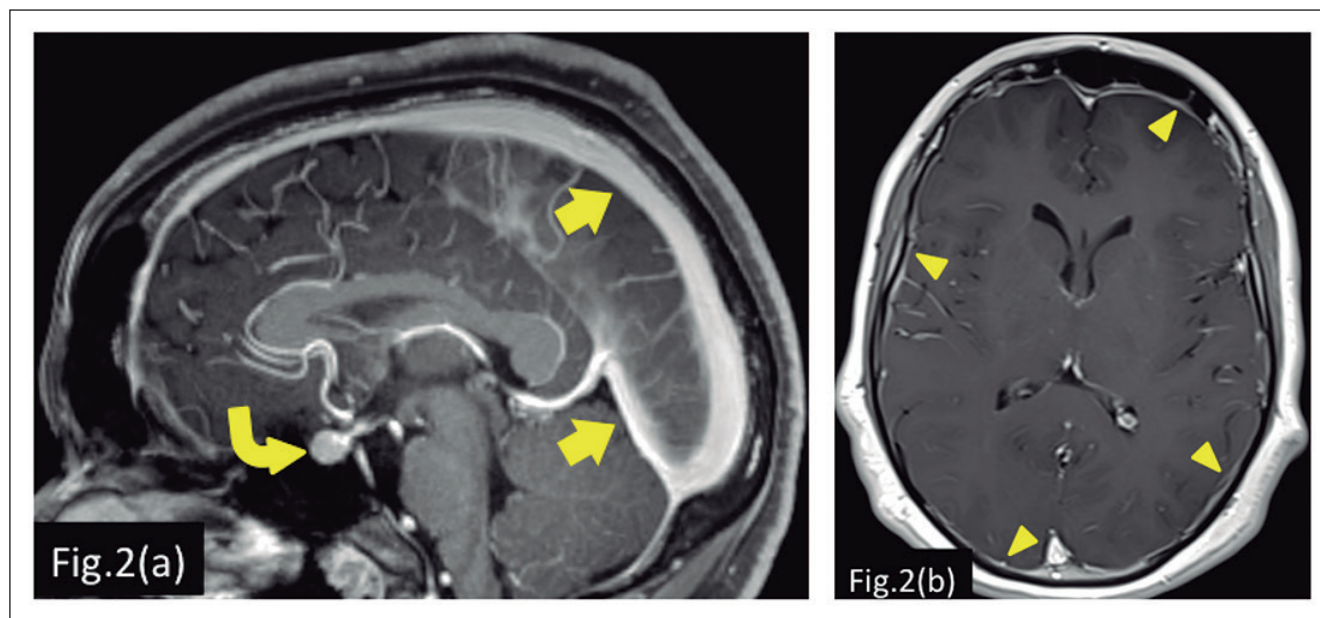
The use of intravenous contrast is essential for the characterization of other signs of endocranial hypotension visible on brain MRI. A: Brain MRI in sagittal T1 sequence with contrast, evidence of ingurgitation of the upper sagittal and rectal dural venous sinuses (arrows). There is also enlargement of the pituitary gland (curved arrow). B: Brain MRI in axial T1 sequence with contrast, shows bilateral symmetrical supratentorial dural thickening and enhancement (arrowhead).
